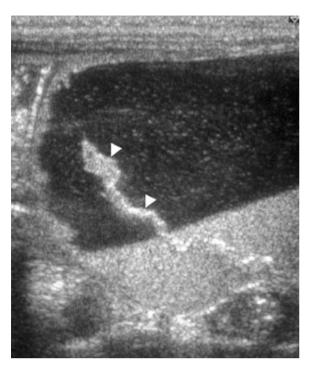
Congenital ovarian cyst in a newborn of diabetic mother complicated by torsion. Longitudinal sonogram of the right hemiabdomen shows a large cyst with low-level echoes, a fluid-debris (blood) level, and an undulating thick membrane (fibrin; *arrowheads*). The cyst decreased in size and resolved completely
